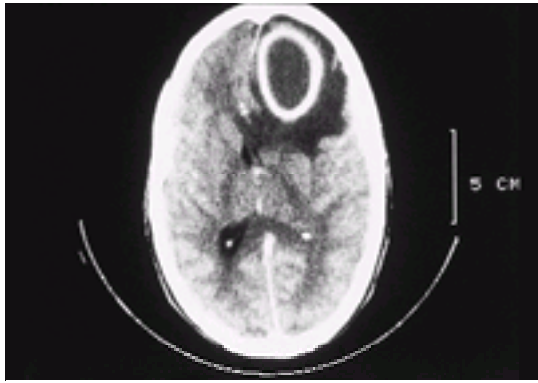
CT scan to show a frontal-lobe abscess: the regular ring shadow with marked surrounding oedema is characteristic.
